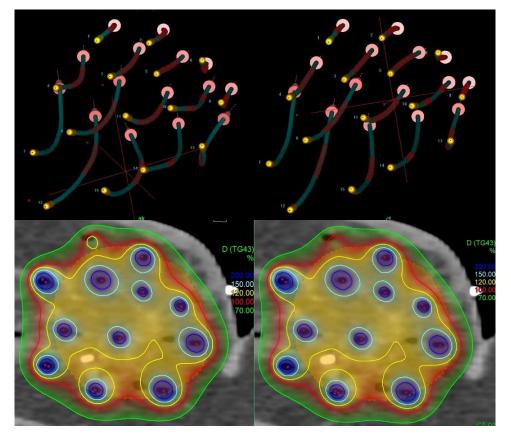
Compared are planning-CT and control-CT situation of the patient showing the maximum dwell position deviation of 14.5mm treated without breast positioning control. The catheter paths were partly completely twisted or shifted, resulting in dosimetric decreases within the target volume (e.g., the 120% isodose volume was much smaller in the control-CT than in the planning-CT).
